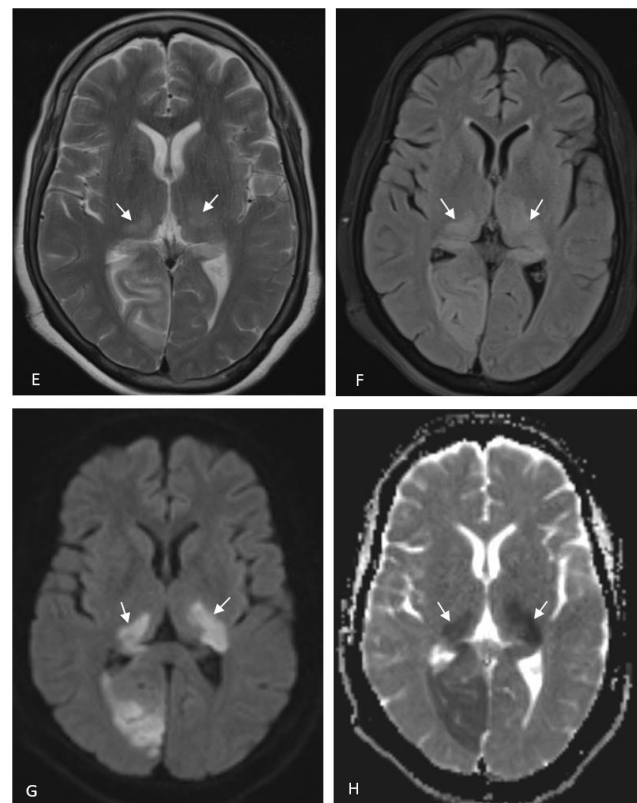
MRI T2 (E), flair (F), and diffusion-ADC (G-H) showing area of bilateral thalamic territory infarction (white arrows)
